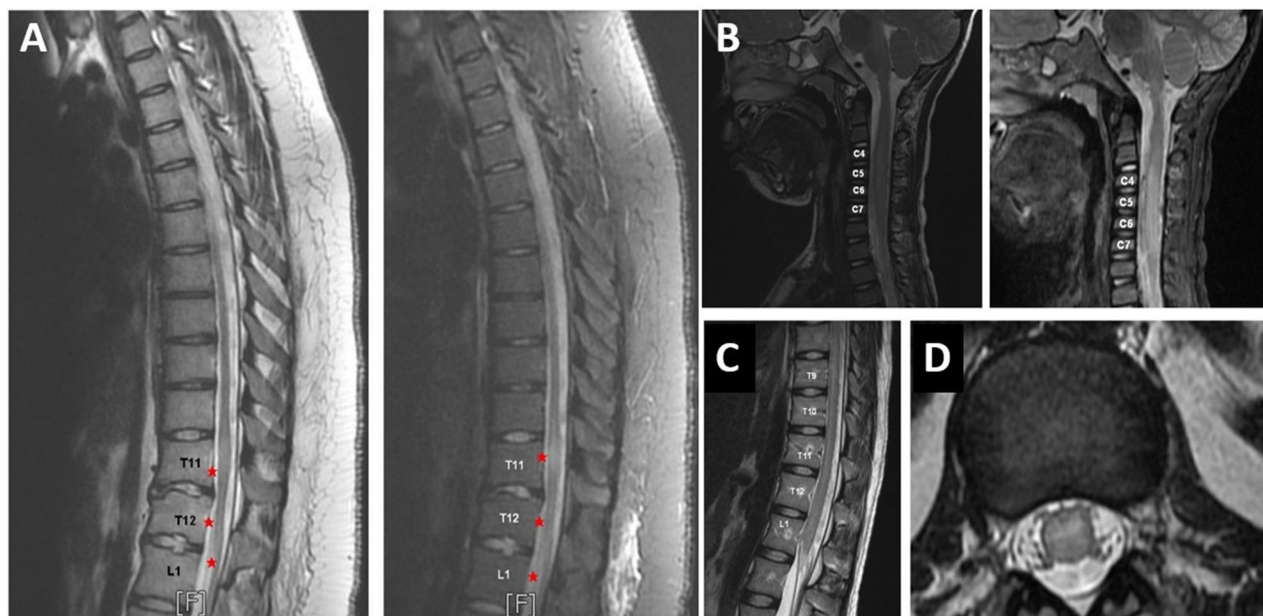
Detailed Interpretation and Figure Legends for MRI Images of selective patients with Myelitis. (A) Sagittal T2W (left) and STIR (right) MRI of the thoracolumbar spine in a 17-year-old female with multiple sclerosis. Vertebral levels T11, T12, and L1 are labeled, with red stars indicating hyperintense lesions due to demyelination. (B) Sagittal T2W (left) and STIR (right) MRI of the cervical spine of a 4-year-old male with Enterovirus D68 infection. Vertebral levels C4, C5, C6, and C7 are labeled, showing hyperintense signals indicative of myelitis. (C) Sagittal and axial T2-weighted MRI of the thoracolumbar spine of an 18-year-old female with Systemic Lupus Erythematosus. Vertebral levels T9, T10, T11, T12, and L1 are labeled. The sagittal view shows hyperintense lesions, and the axial view at T12-L1 highlights spinal cord inflammation consistent with myelitis. MRI, Magnetic Resonance Imaging; T2W, T2-Weighted; STIR, Short Tau Inversion Recovery; MS, Multiple Sclerosis; EV-D68, Enterovirus D68; SLE: Systemic Lupus Erythematosus
